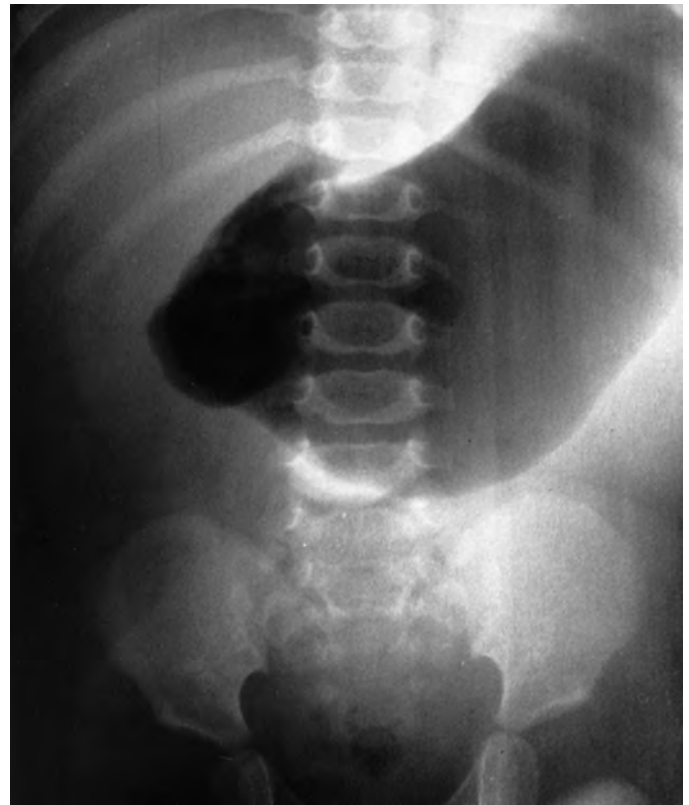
Midgut volvulus. Plain radiograph demonstrates air only in the stomach and duodenum in this acutely ill infant with midgut volvulus.
